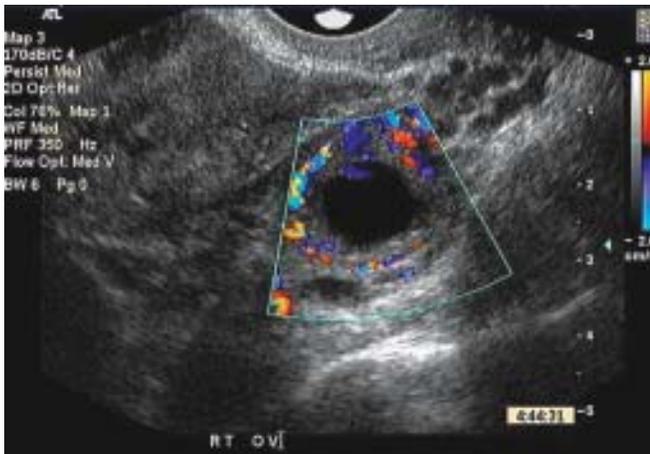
Color Doppler image of the ovarian blood flow in the luteal part of the menstrual cycle
